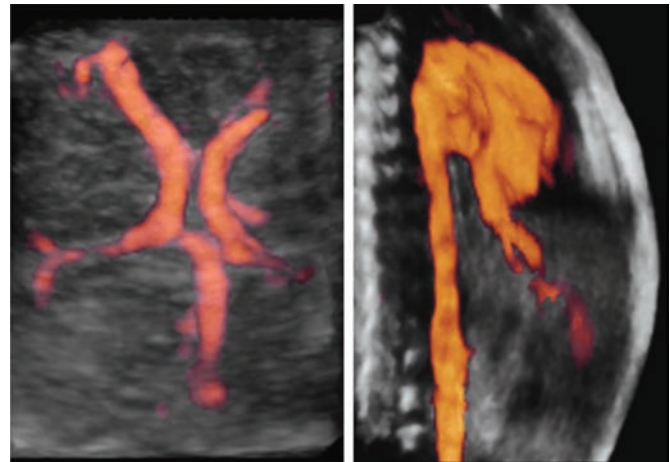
Glass body rendering: the combination of transparent mode and power Doppler displays the vascular system of the fetus. Left, circle of Willis (35 weeks); right, fetal heart and aorta (30 weeks).
